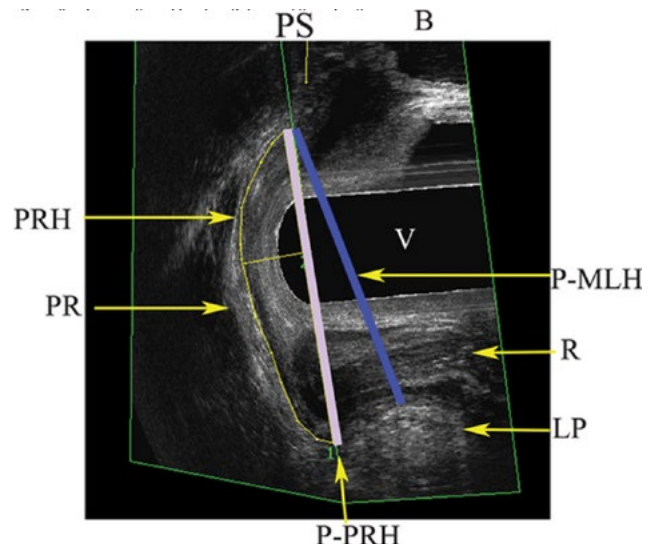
Ultrasound showing plane of MLH and PRH in the right sagittal view. Abbreviations: B, bladder; LP, levator plate; P-MLH, plane of MLH (blue line); P-PRH, plane of puborectalis hiatus (purple line); PR, puborectalis; PS, pubic symphysis; R, rectum; V, vagina (1).
